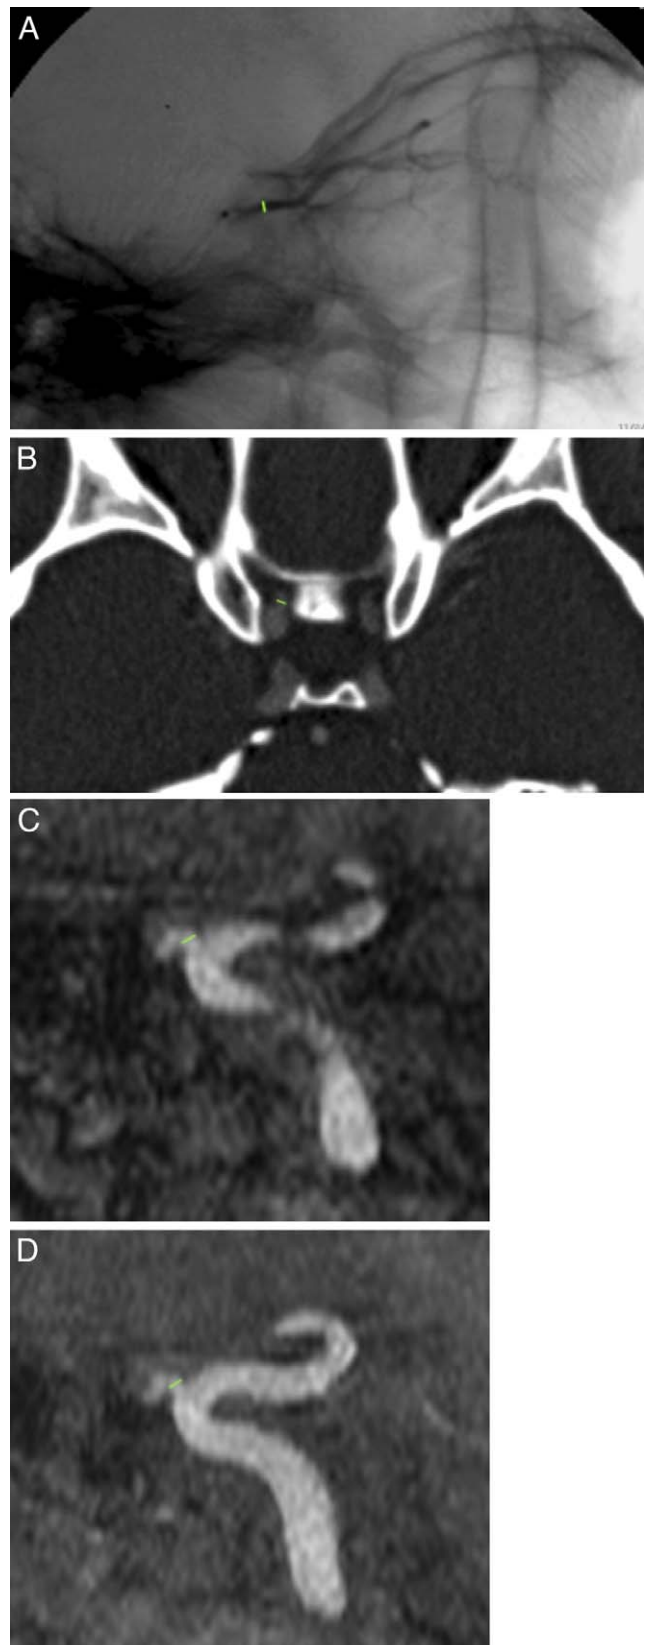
Lateral image of a super-selective angiogram of a NHP OA (A), with a measurement between the level of the ophthalmic origin and the orbital apex. Axial CT angiographic image showing a measurement of the OA diameter shortly after the origin (B). A sagittal reformat of an MR angiogram (C) as well as a sagittal maximum-intensity projection of the same MR angiogram (D) demonstrating the location of the measurement.
